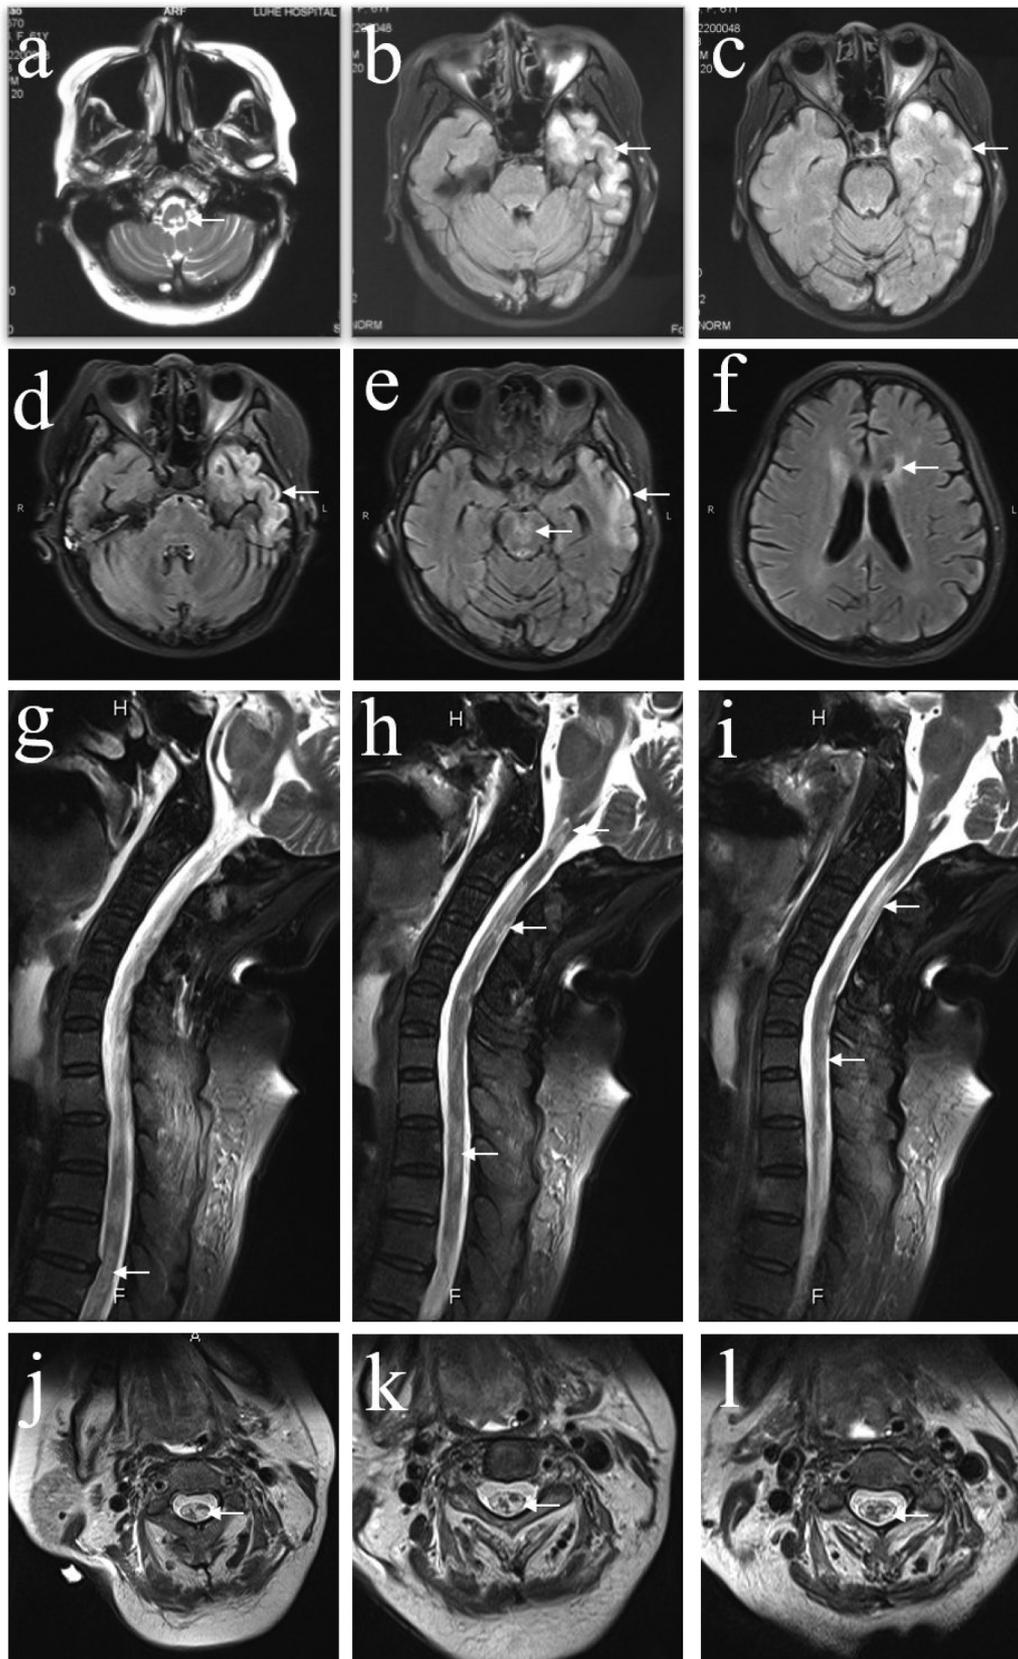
Brain and spinal cord MRIs of the patient. Four days prior to admission, T2-weighted and T2-weighted FLAIR MRI showed abnormal hyperintense signals in the medulla oblongata (a) and the left temporal pole (b and c). Six weeks after admission, T2-weighted FLAIR and T2-weighted MRI showed multiple hyperintense lesions within the left temporal lobe (d and e), midbrain (e), white matter around the bilateral lateral ventricles (f), medulla oblongata, cervical medulla and upper thoracic medulla (g–l)
